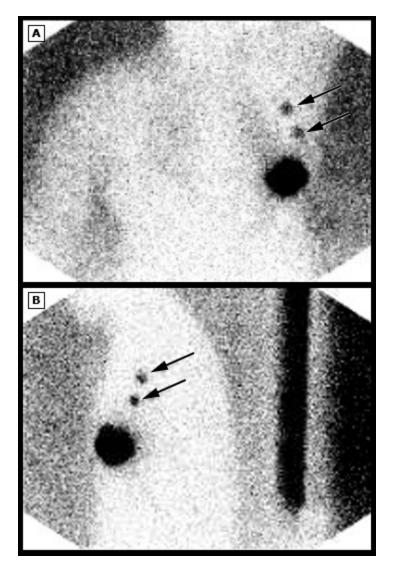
Figure A (anterior projection) and B (lateral projection): Lymphoscintigraphy using technetium sulfur colloid demonstrates two foci of posterior and superior migration of the radiopharmaceutical into the axilla.
